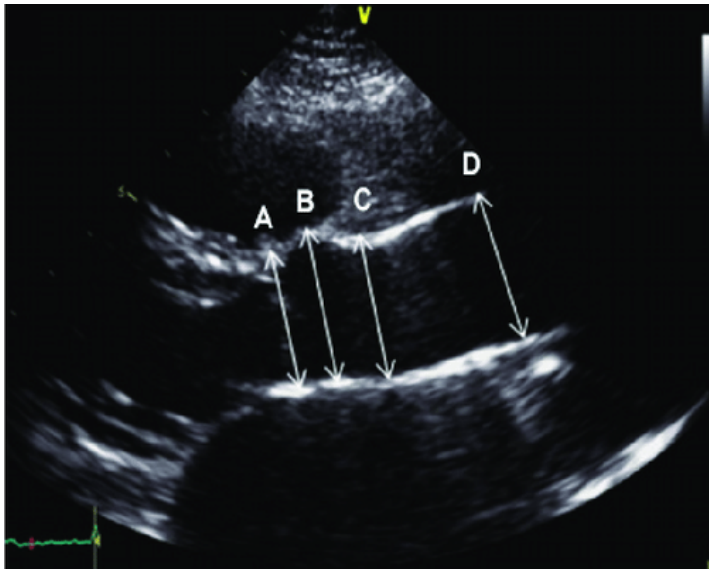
The parasternal long-axis view: A aortic annulus tract, B aortic sinuses, C sinotubular junction and D ascending aorta. Source: Adapted from Upadhyaya et al. 2021.^[248]
